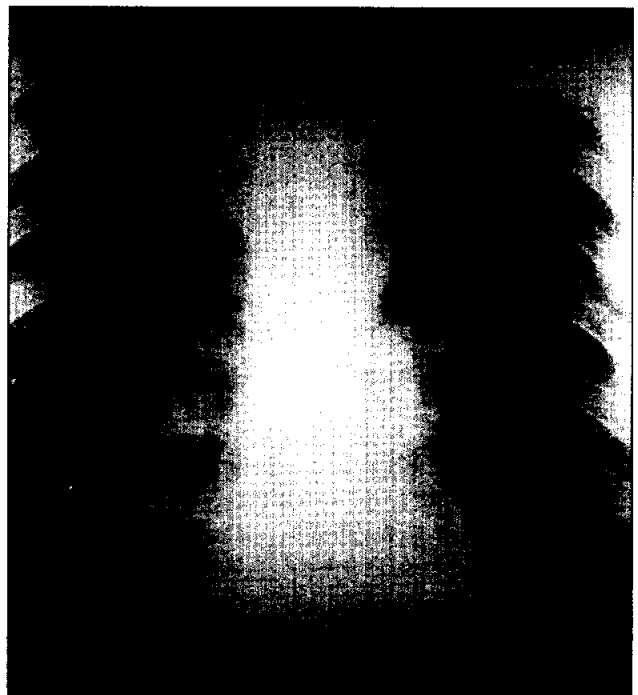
Chest X-ray of patient 2 showing miliary shadows
